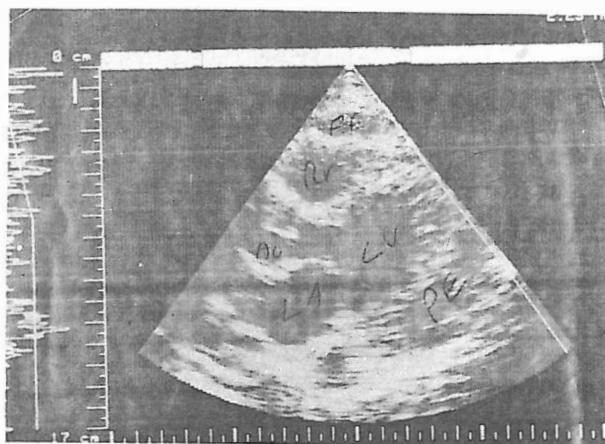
Two-dimensional echocardiography of the patient demonstrating massive pericardial effusion.
